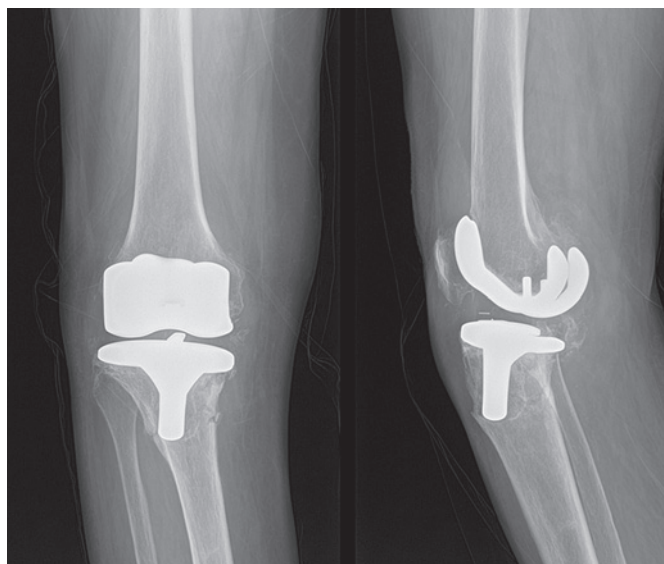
Radiographic imaging of a loose TKA in anteroposterior and lateral views (patient No. 6). Although preoperative cultures were negative, implant removal was necessary due to prosthetic loosening. *Coagulase-negative Staphylococcus* was detected exclusively through PCR analysis following sonication.
